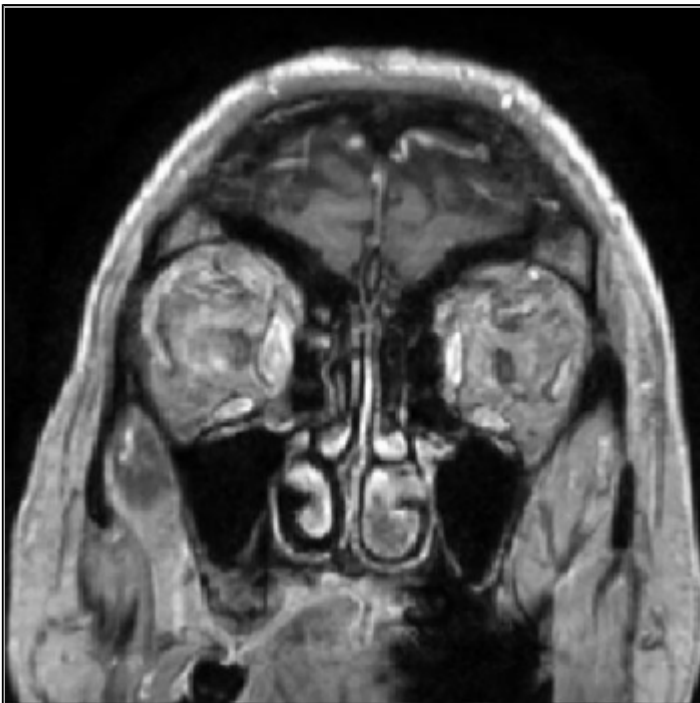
Diagnostic orbital MRI
